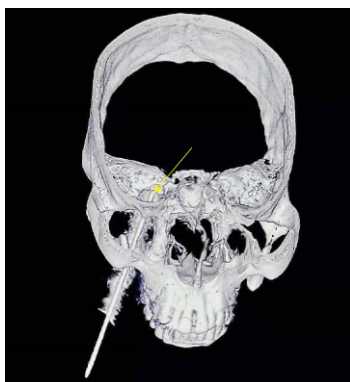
Computed tomographic three-dimensional skull reconstruction image showing the introducer needle and coblation wand (yellow arrow), which pierced the needle into the foramen ovale and reached the target nerve.
